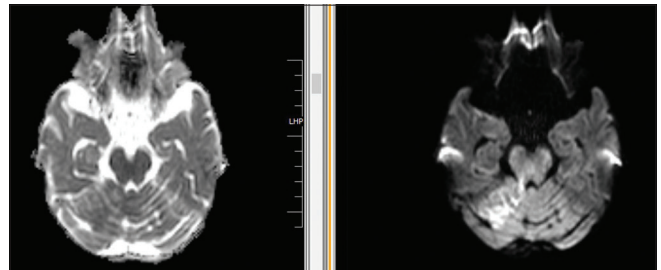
Acute infarct of the cerebellum on magnetic resonance imaging: T2-weighted image (left) and T1-weighted image (right)
